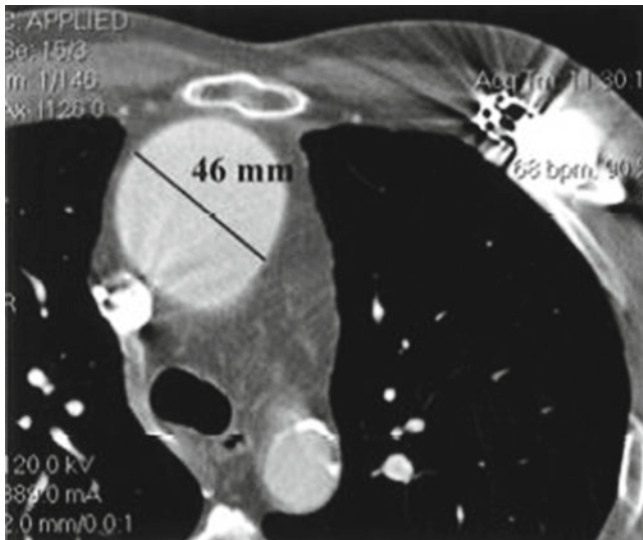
A 64-slice CT angiogram of a 20-year-old man with Marfan syndrome. (a) Sagittal cut demonstrating the characteristic “Erlenmeyer flask” appearance of the aortic root (Ao). The aorta measured 53 mm at the level of the sinuses, spurring a referral for surgical
